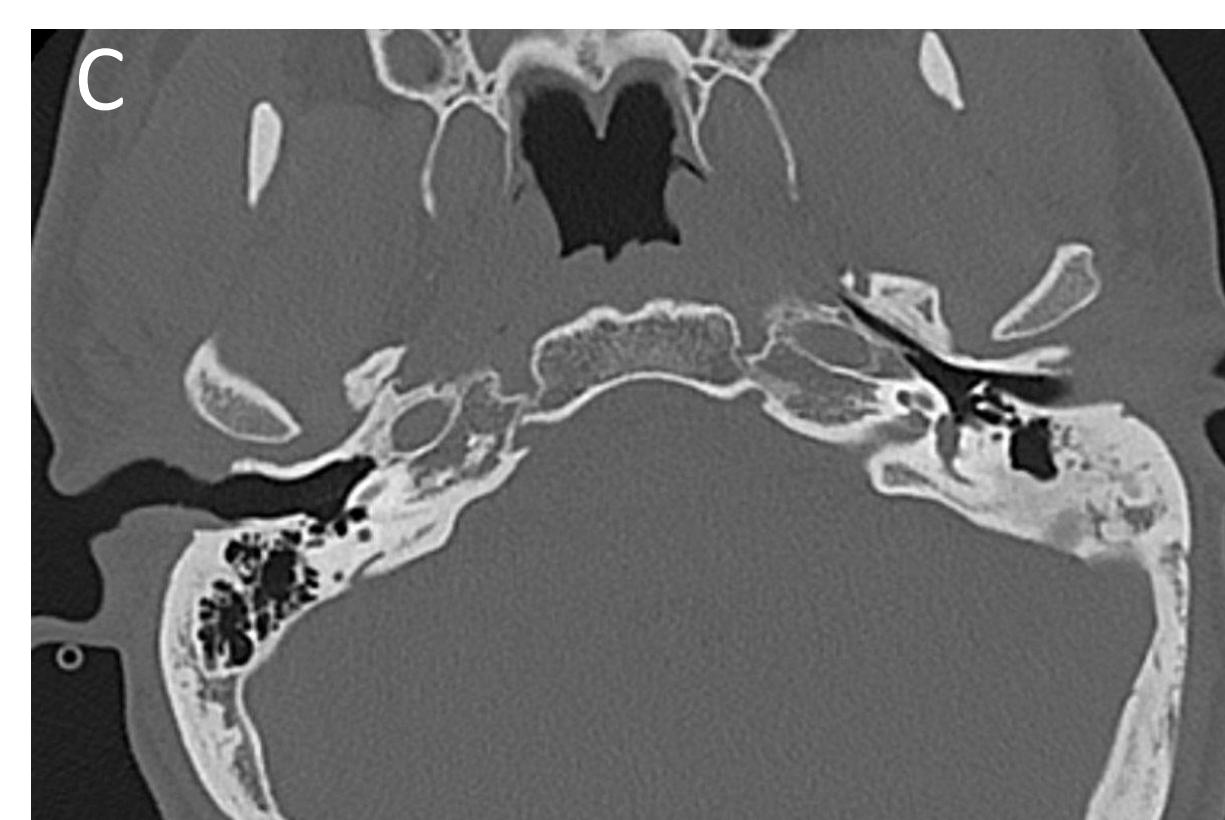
Axial CT shows highly pneumatized mastoid air cells on the right and sclerotic air cells on the left.
